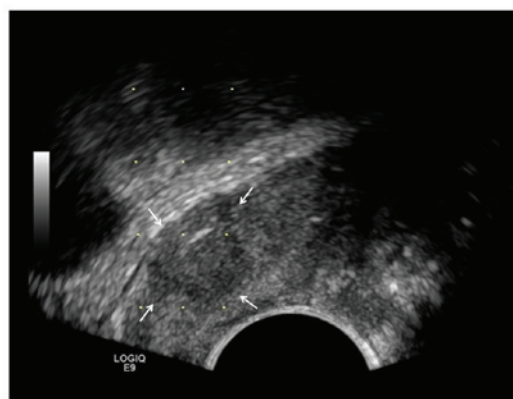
TVUS of a 62/F patient with cervical cancer. Biopsy was taken at the cervix. A 2.8x2.3 cm mass is indicated by the white arrows. TVUS, transvaginal ultrasound.
